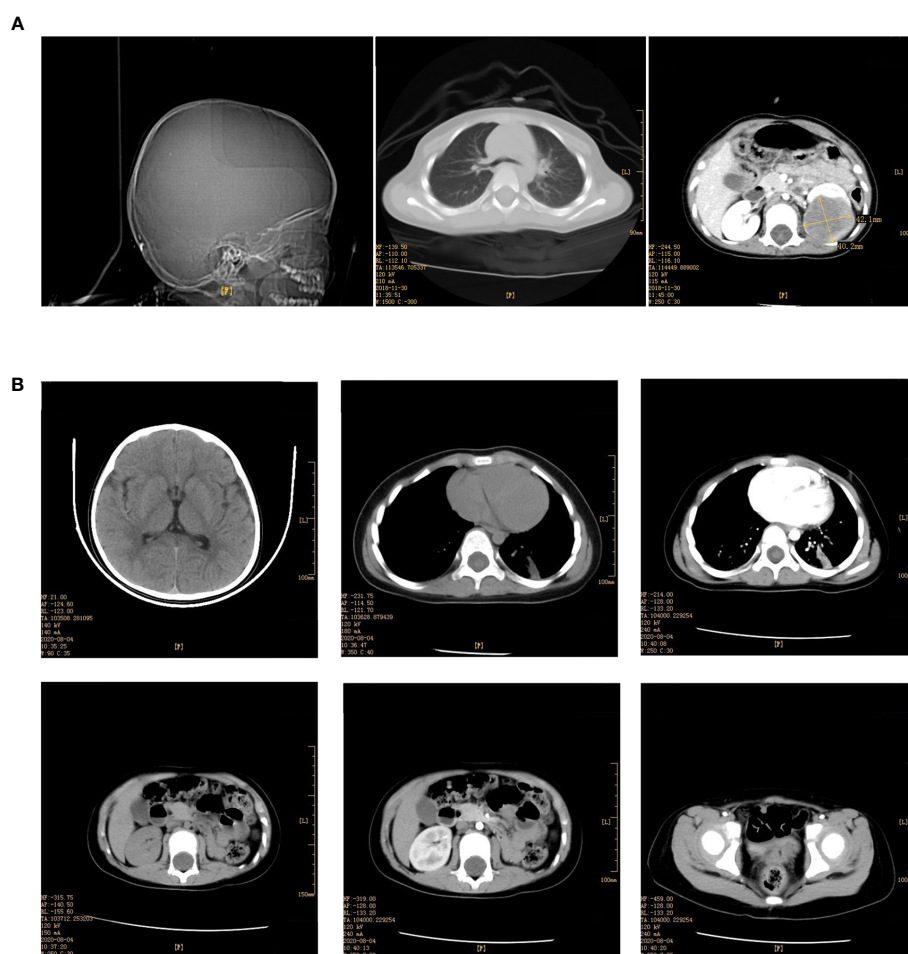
(A) Enhancement of skull, chest, whole abdomen CT plain scan before the operation (December 03, 2018). (B) Enhancement of skull, chest, whole abdomen CT plain scan after the operation (August 04, 2020).
